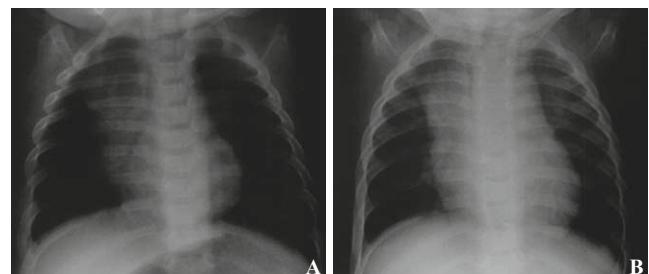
Chest X-ray taken before (A) and after (B) development of mitral valve stenosis/regurgitation.
